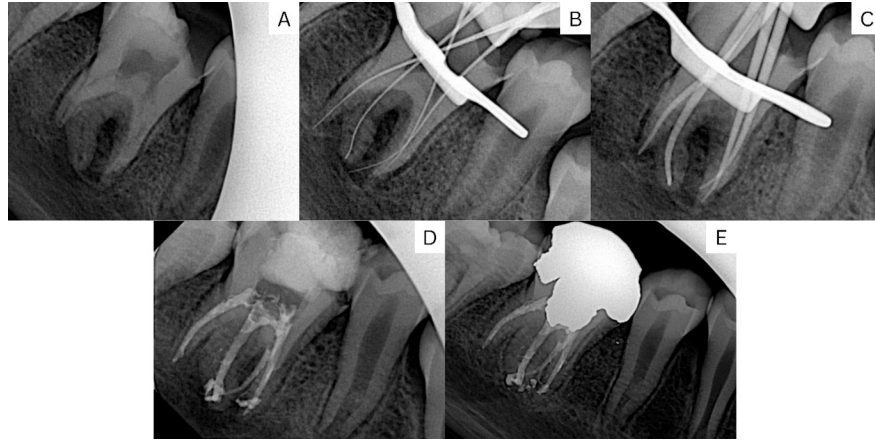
Figure Mandibular right first molar: A) initial radiograph, extensive mesial caries, widening of PDL, double curvature (Bull's eye view); B) working length determination; C) cone fit confirmation; D) final radiograph, obturation, apical seal, temporary restoration; E) 8-month follow-up, coronal seal
